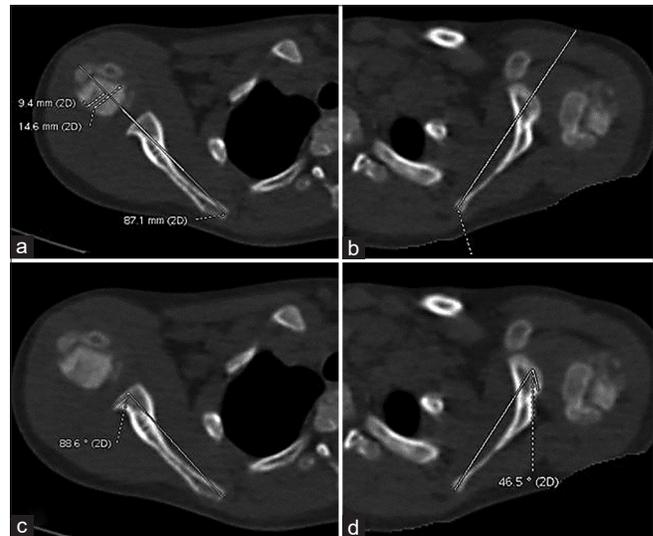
Computed tomography axial images of a 5-year child with the left obstetric brachial plexus injury. (a) Percentage of humeral head anterior to the scapular line (PHH) in normal side [right]. (b) PHH in affected side [left] showing posterior shoulder dislocation. (c) Glenoscapular angle (GSA) in normal side [right] 1.4° retroversion. (d) GSA in affected side [left] showing increased glenoid retroversion of 43.5°.
